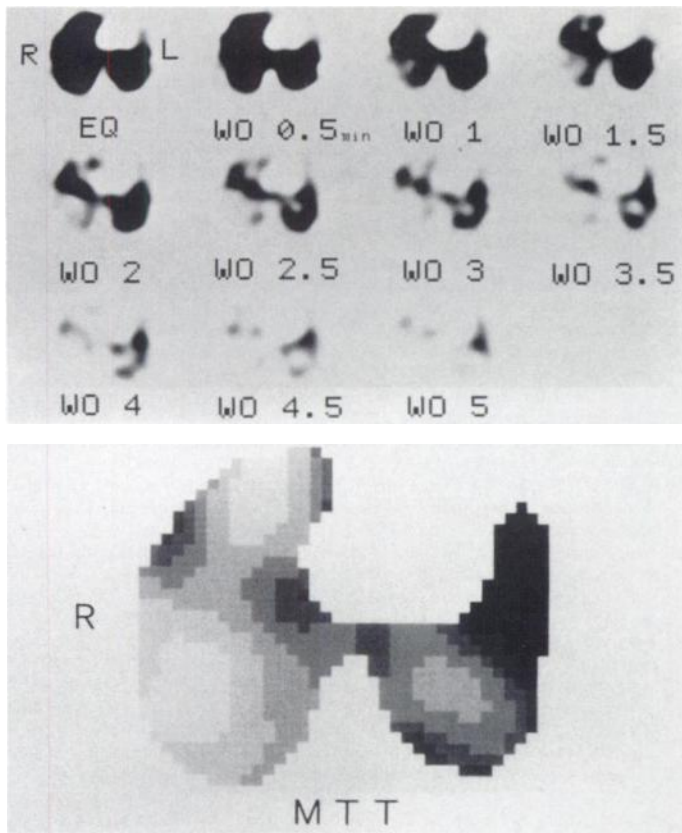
SPECT image from a 59-yr-old woman with bronchial asthma shows heterogeneous ^{133}Xe retention in both lungs (top). Chest CT scan does not show any abnormalities. MTT image shows heterogeneously prolonged MTT in both lungs (bottom).
